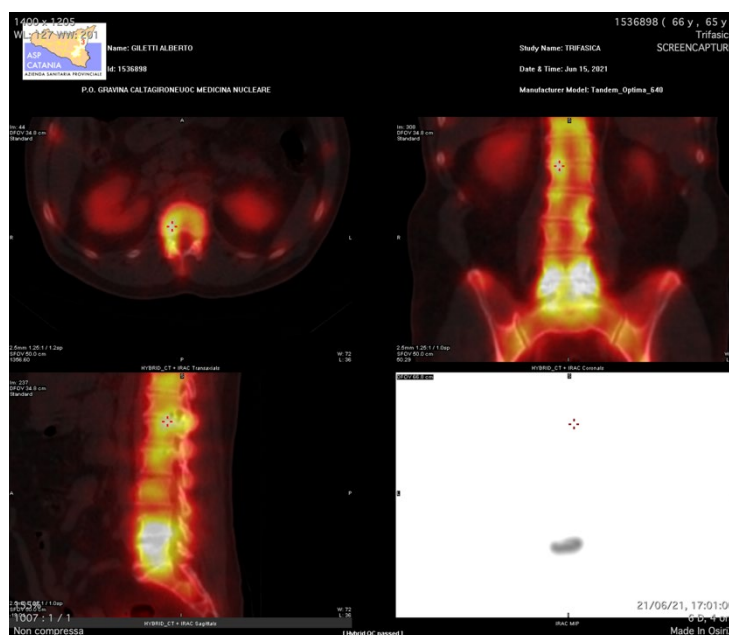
66 years male with chronic LBP for 3 years. SPECT-CT on axial, sagittal and coronal recons. Bone scanning clearly depicts severe Tc99 uptake at the L4 and L5 vertebral bodies, confirming the presence of aseptic spondylodiscitis related to chronic mechanical trauma, presumably secondary to disc degeneration.
